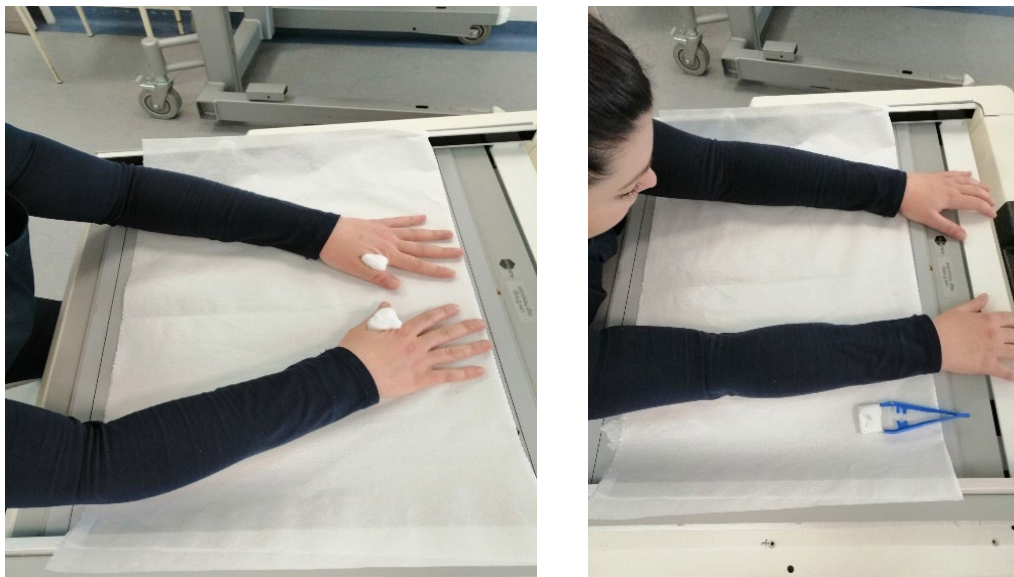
Positioning of the patient for lymphoscintigraphy of the upper extremities after the subcutaneous administration of ^{99m}Tc nanocolloid in the first interdigital space of each hand.
